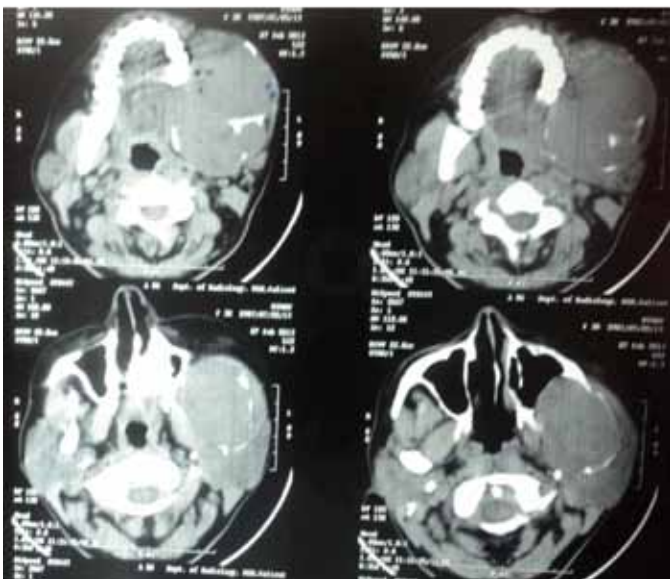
Computed tomography (CT) scan showing the lesion.
